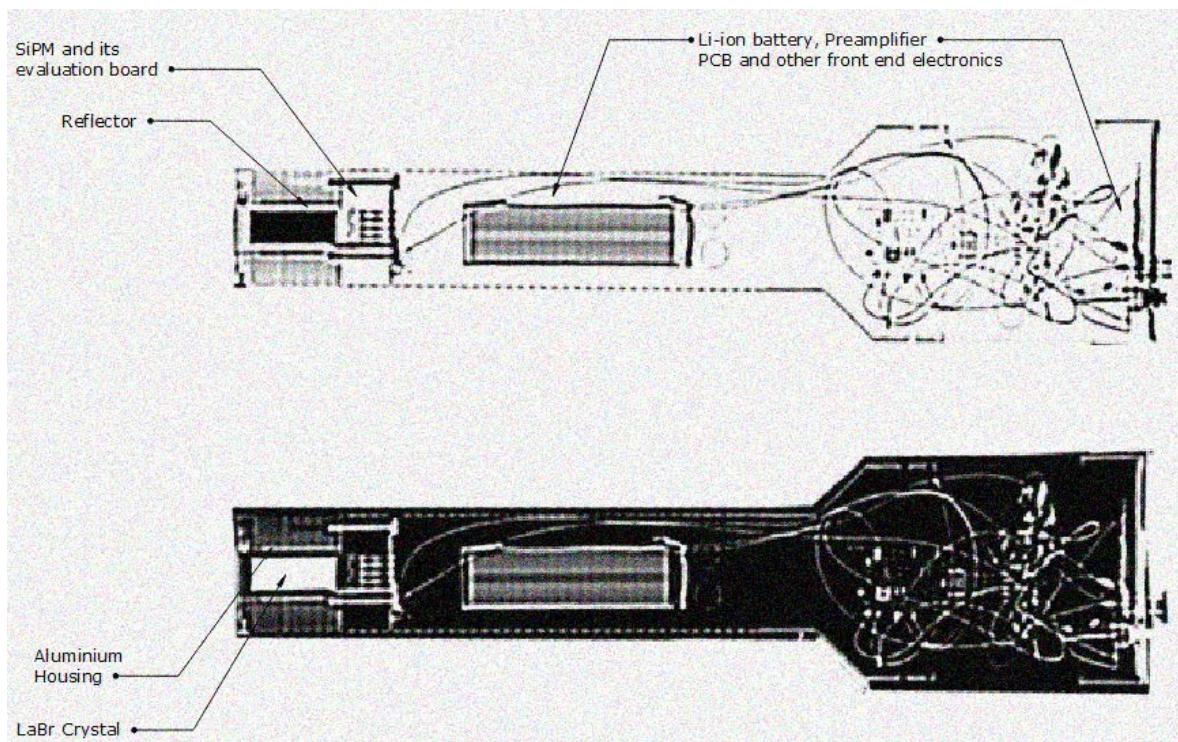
A planar reconstruction from a CT scan of the detector unit, in grayscale and inverse grayscale.
